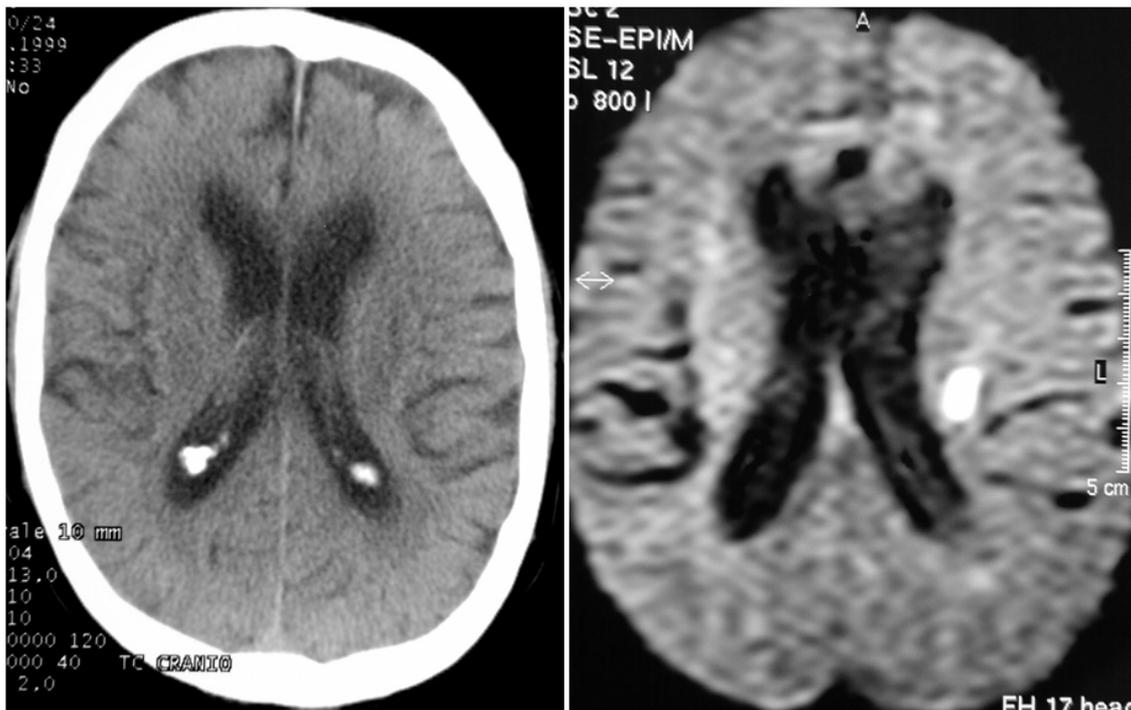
DWI (right) is more sensitive than CT (left) in detecting the ischemic lesion.
